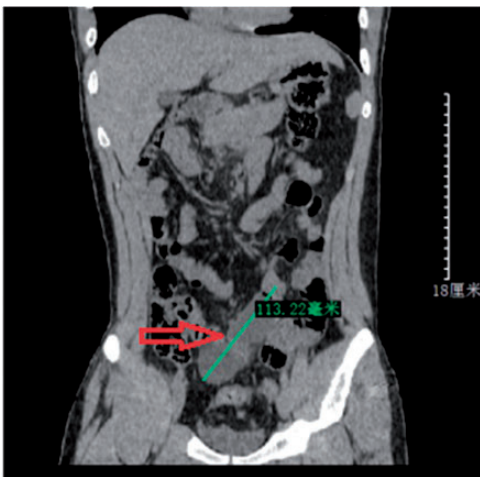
The initial computed tomography image showing a blind-ending pouch structure representing Meckel's diverticulum.
